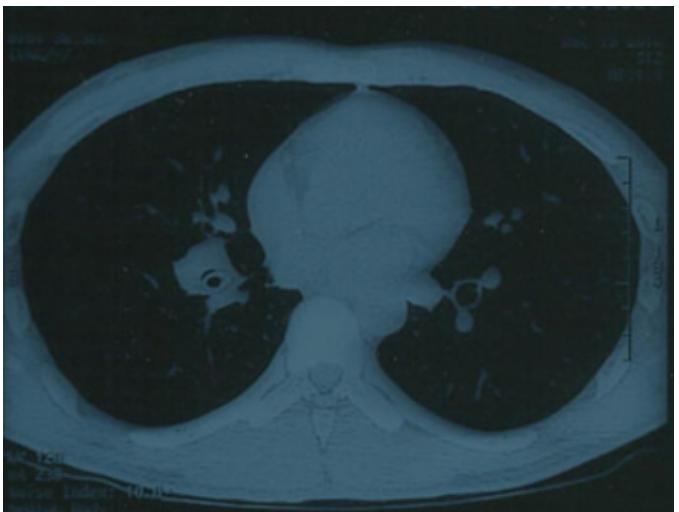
CT thorax showing lodgment of bone as stent inside right bronchus intermedius
